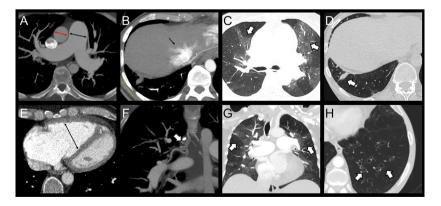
Extravascular findings of chronic thromboembolic pulmonary hypertension. (A-F) 65-year-old woman with suspected chronic thromboembolic pulmonary hypertension (CTEPH). (A), CT image in the axial plane obtained after intravenous administration of iodinated contrast material (ICM) shows enlarged pulmonary artery (PA) trunk > 29 mm (black double arrow) and pulmonary artery-aorta ratio > 1 (red double arrow). (B), CT image shows reflux and mild enlargement of the hepatic veins (arrow). (C), CT image in the axial plane using lung window shows mosaic pulmonary pattern (arrows). (D), CT image in the axial plane using lung window shows healed pulmonary infarcts (white arrow). (E), CT image shows right ventricular enlargement and rectification of the interventricular septum (black double arrow). (F), CT image in the coronal plane using lung window shows hypertrophic bronchial arteries (arrow). (G), CT image in the over left lobe (arrows). (H), 46-year-old man with confirmed CTEPH. CT image in the axial plane obtained without ICM shows mild bronchiectasis in the lower left lobe (arrows).
